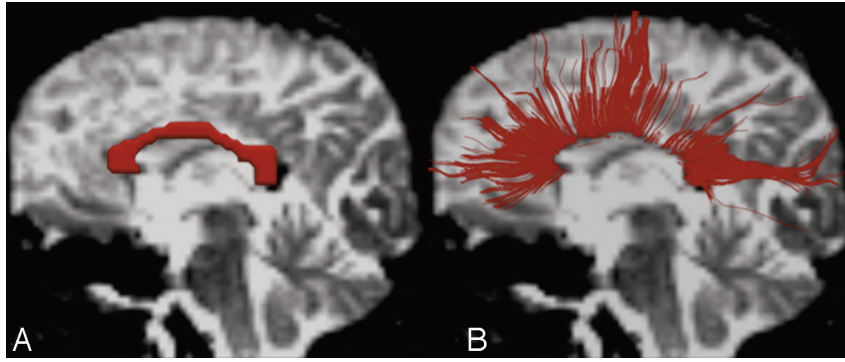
Regions of interest (ROIs) of the corpus callosum (CC) and interhemispheric fibers. *A*, A single ROI is placed in the midline CC in the midsagittal plane for studying callosal fibers on the background of a $b = 0$ T2-weighted image.²⁹ The ROI is red. *B*, Left lateral view of a 3D reconstruction of callosal fibers passing through the genu, body, and splenium of the CC in the background of a $b = 0$ T2-weighted image.
